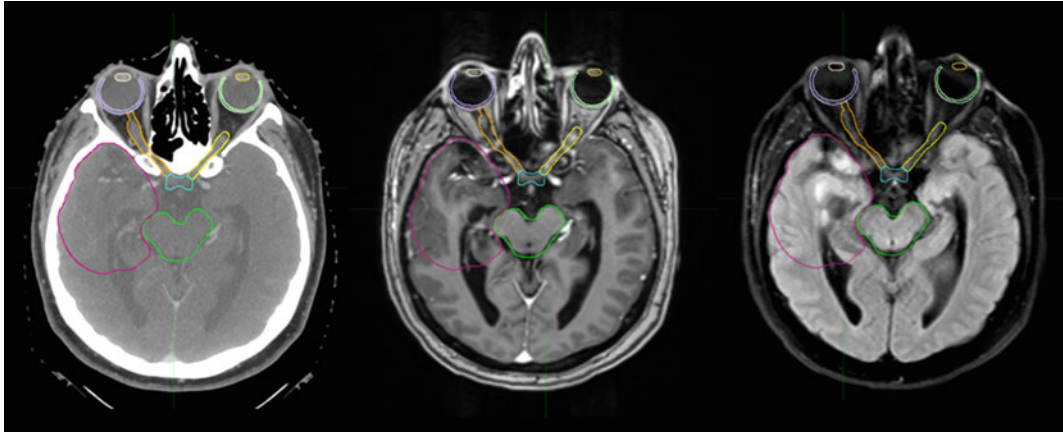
Clinical target volume (CTV) is outlined (pink) on representative slices at the same level from the planning computed tomography (CT), T1-weighted post-gadolinium, and T2-weighted FLAIR magnetic resonance imaging (MRI) series, respectively, from *left* to
